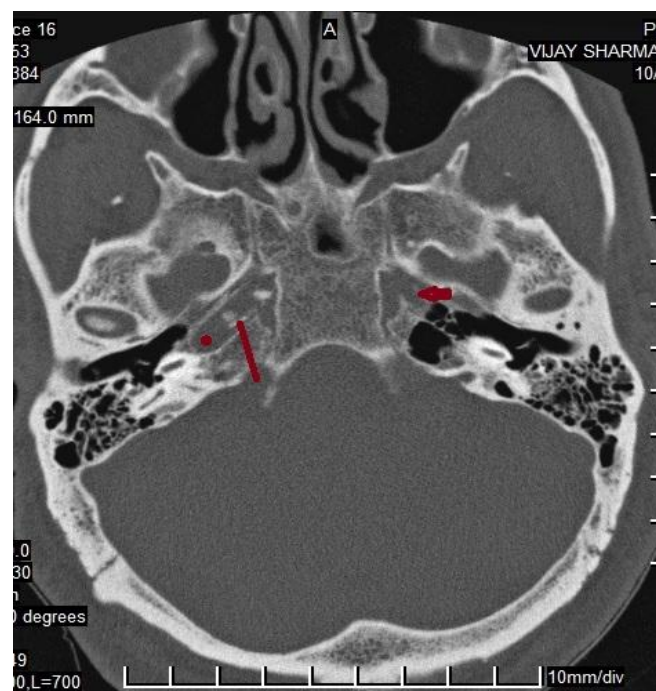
Non-contrast-enhanced, thin section axial CT, temporal bone window technique showing the absence of the left carotid canal (red arrow) with normal right carotid canal (red dot) atherosclerotic calcification in right ICA (red line).
